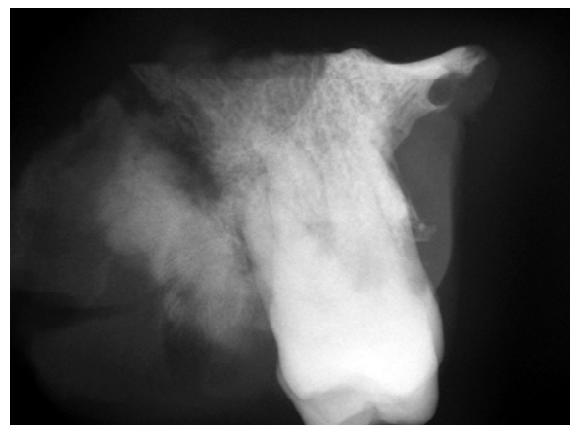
Radiographic picture of osteosarcoma showing ‘sun-ray appearance’
